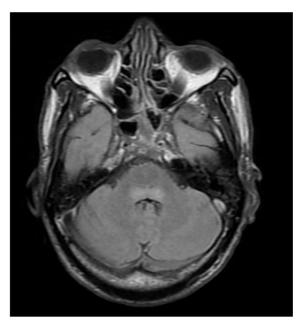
MRI scan case 2
